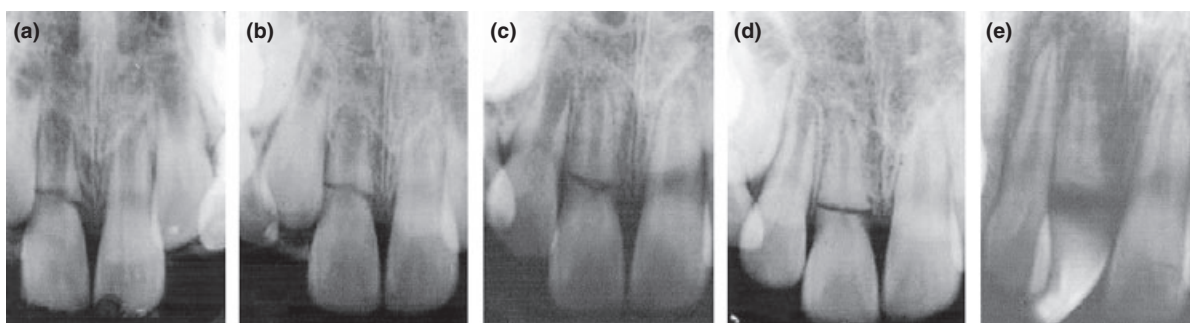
Second luxation of the coronal fragment. (a) An immature incisor with horizontal, cervical root fracture. (b–d) Radiographs taken after 2, 9 and 17 months show healing with interposition of soft tissue between fragments. (e) After 49 months the tooth suffered a new luxation injury of the coronal fragment and the tooth had to be extracted [from Cvek et al. (11)].
